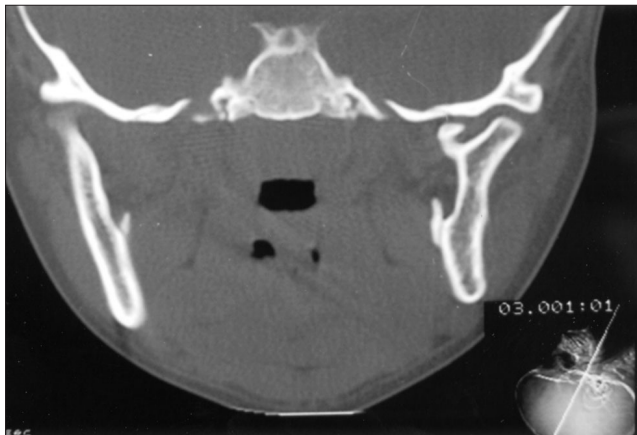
Coronal computed tomography section with X, Y and Z axes, obtained at the 4-year follow-up, indicates bifid mandibular condyle on the right side.
